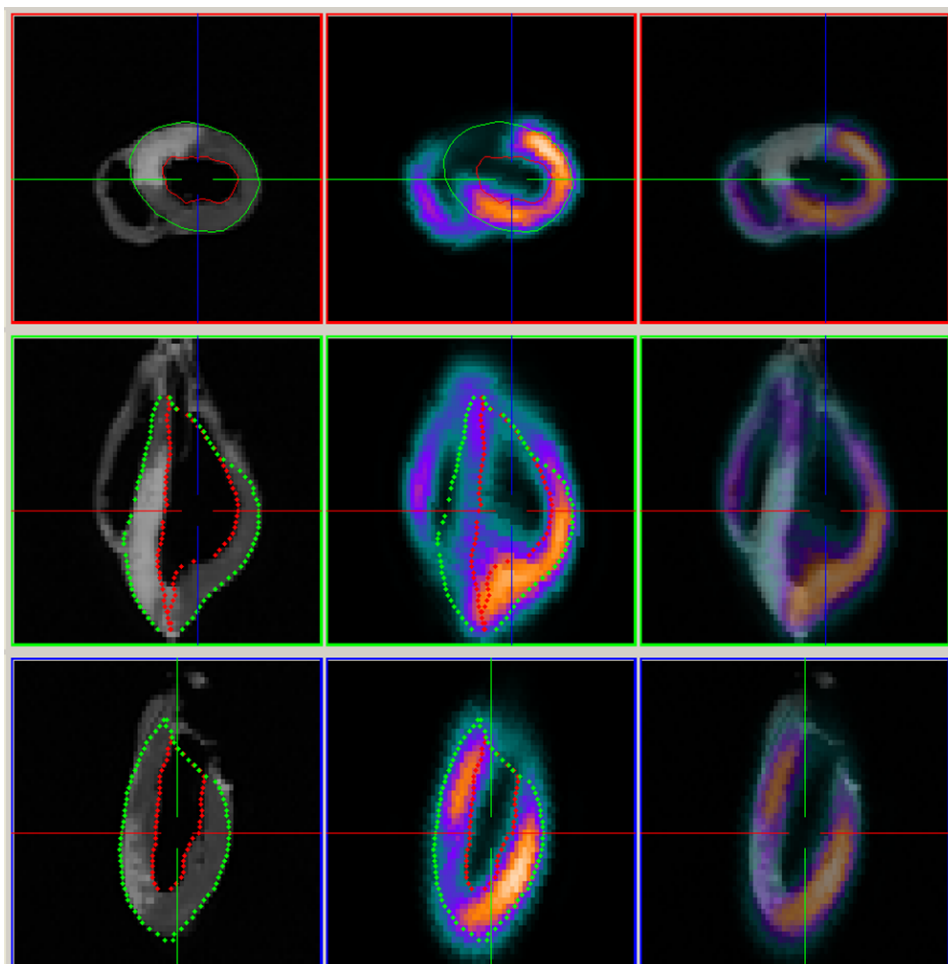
Reproduced from Demidova et al.^[92] Images representing MaR and final IS after experimentally induced ischemia. Left column: MRI performed for visualization of the ant infarction. Dark gray indicates viable myocardium and white indicates infarction. Middle column: SPECT used to assess MaR by visualization of the anteroseptal perfusion defect. Warm colors indicate adequate perfusion and cold/absent colors indicate decreased/lack of perfusion. Right column: Fusion of MRI and SPECT images. Endocardial and epicardial borders of the left ventricle were manually delineated in the MRI images and fused with the co-registered SPECT images.
